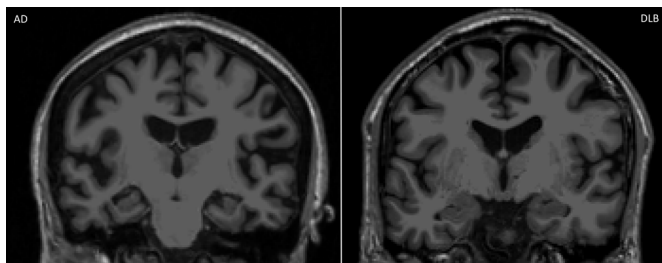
A comparison of coronal T1 MRI scans showing relative atrophy within the hippocampus/temporal lobe in an AD subject (left) compared with a DLB subject (right). Images were provided by Elijah Mak (University of Cambridge, UK). AD, Alzheimer's dementia; DLB, dementia with Lewy bodies.
